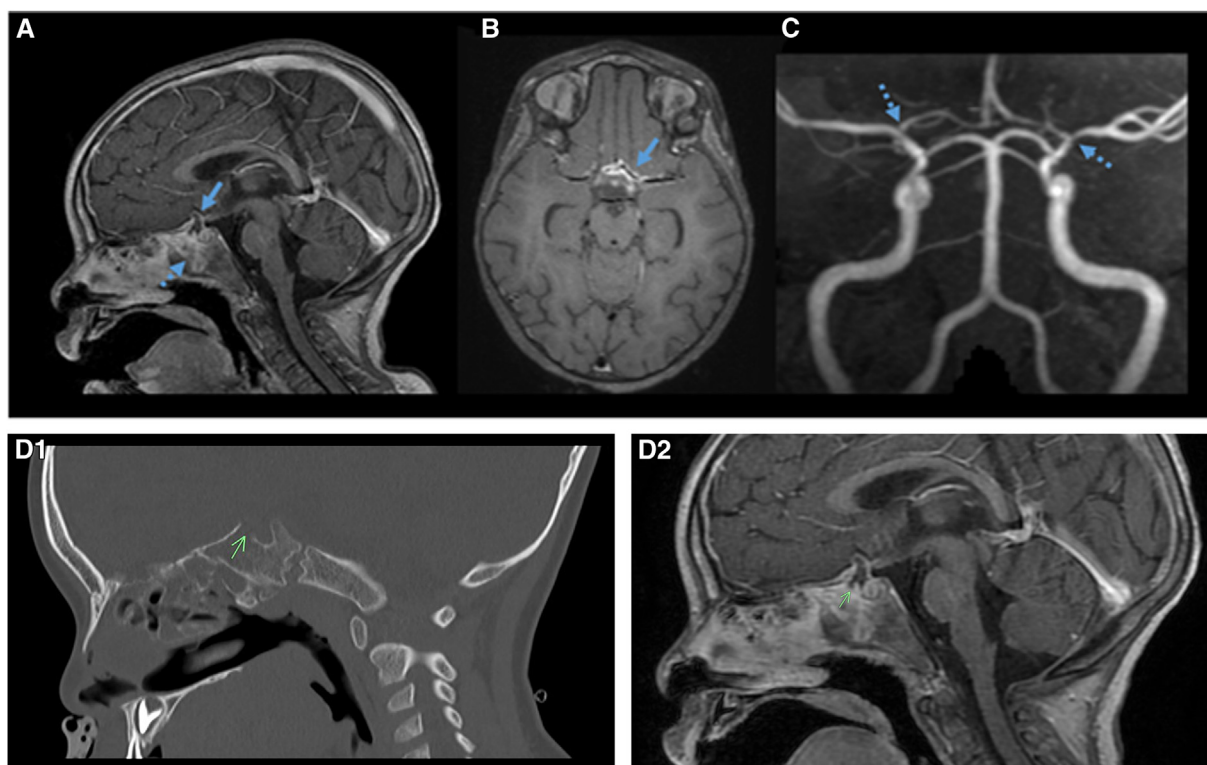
MR images of basisphenoid osteomyelitis with intracranial abscess and vasculitis. A, The small abscess (solid arrow) adjacent to sella turcica and bone marrow enhancement of the basisphenoid. B, Enhancement along the intracranial arteries of the anterior circle of Willis in keeping with vasculitis. C, Corresponding MR angiography showing stenoses at the distal intra-cranial internal carotid artery (ICA), ICA bifurcations, and A1 segments of the ACAs. D, CT images clearly show that the bone defect on CT correlates with location of the extra parenchymal abscess. Note that the abscess has a small finger like projection superiorly. This could represent a trans dural component extending into the subarachnoid space, but still extra parenchymal.
